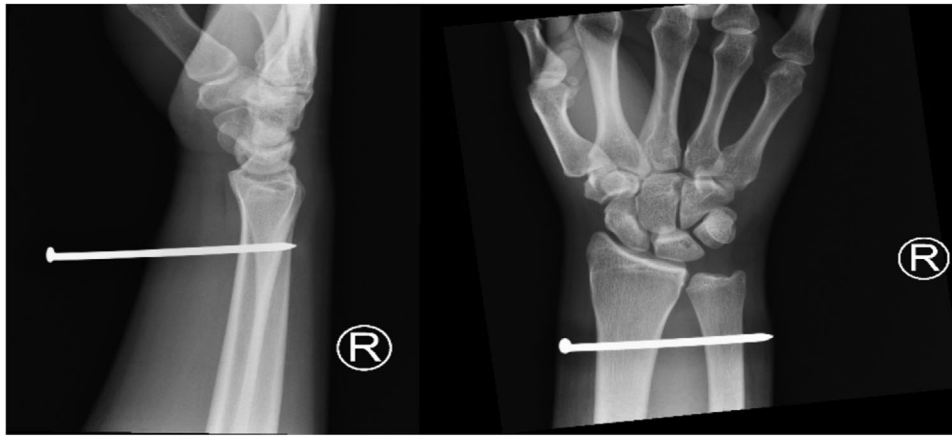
Anterior-posterior and lateral X-ray images showing the distal forearm medial to the ulna impaled by the nail without signs of fracture
